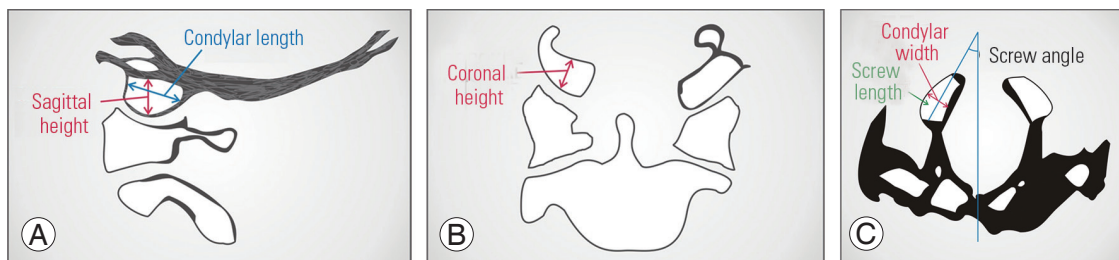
Pictographic representation of condylar measurements taken on sagittal (A), coronal (B), and axial (C) reconstructions of a computed tomography scan.
